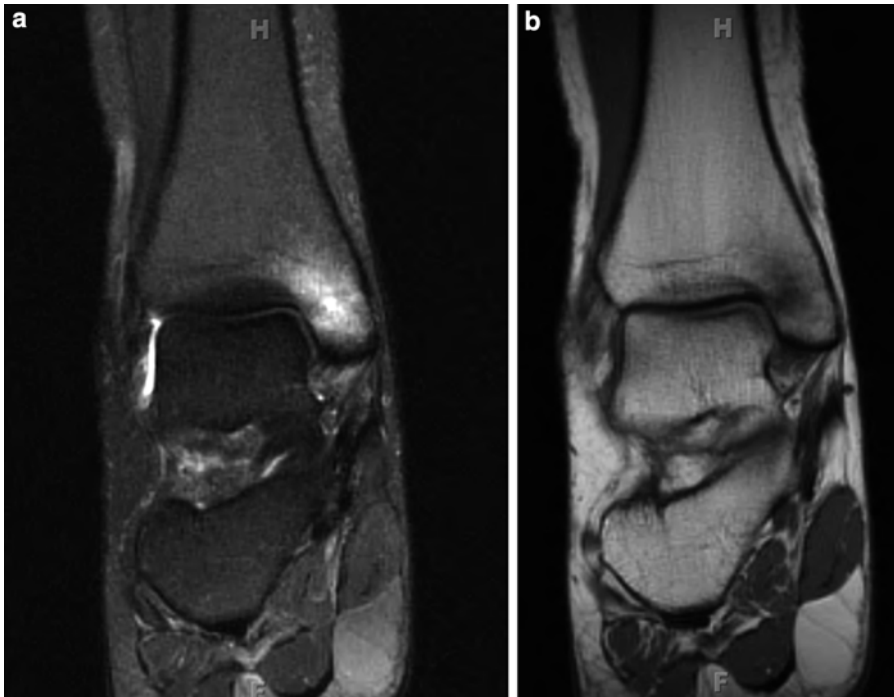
(a) T2-weighted MRI of the patient introduced in Fig. 12.4a. Notice the significant bone edema noted in the medial malleolus. (b) T1-weighted image in the same
